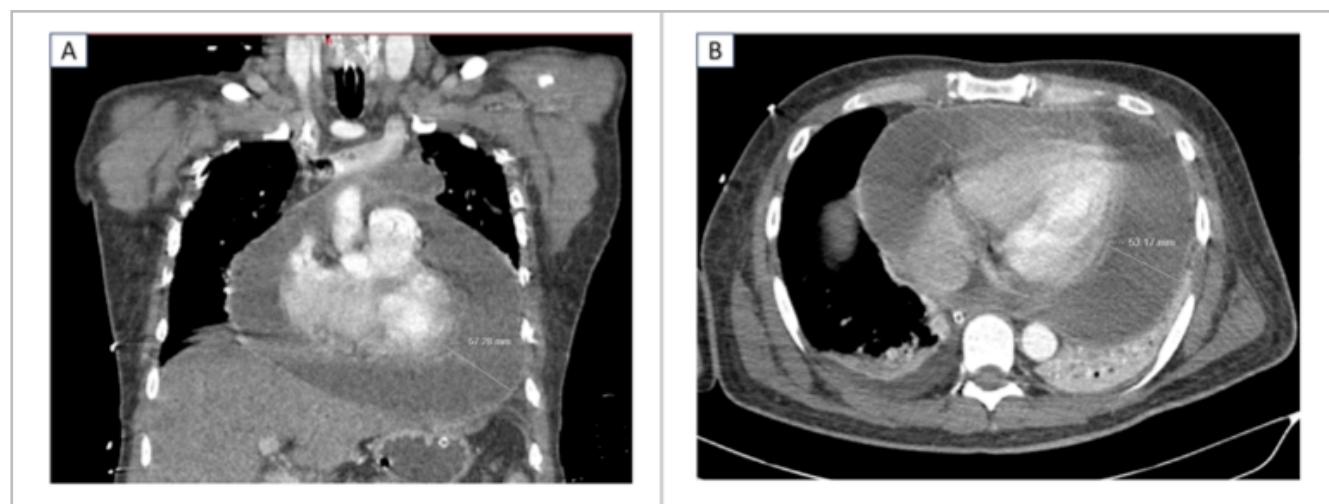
Computed tomography of the chest with contrast Case 2: A: severe pericardial effusion measuring 57.28 mm, viewed in the coronal plane. B: bilateral pleural occupation and severe pericardial effusion measuring 53.17 mm, viewed in the axial plane.
